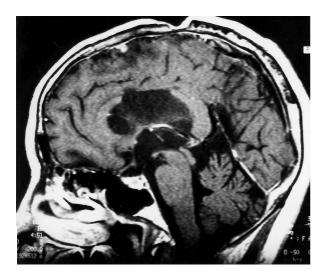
Sagittal MRI performed 3 years after surgery shows small, enhancing, dural-based nodule beneath the bone flap.
